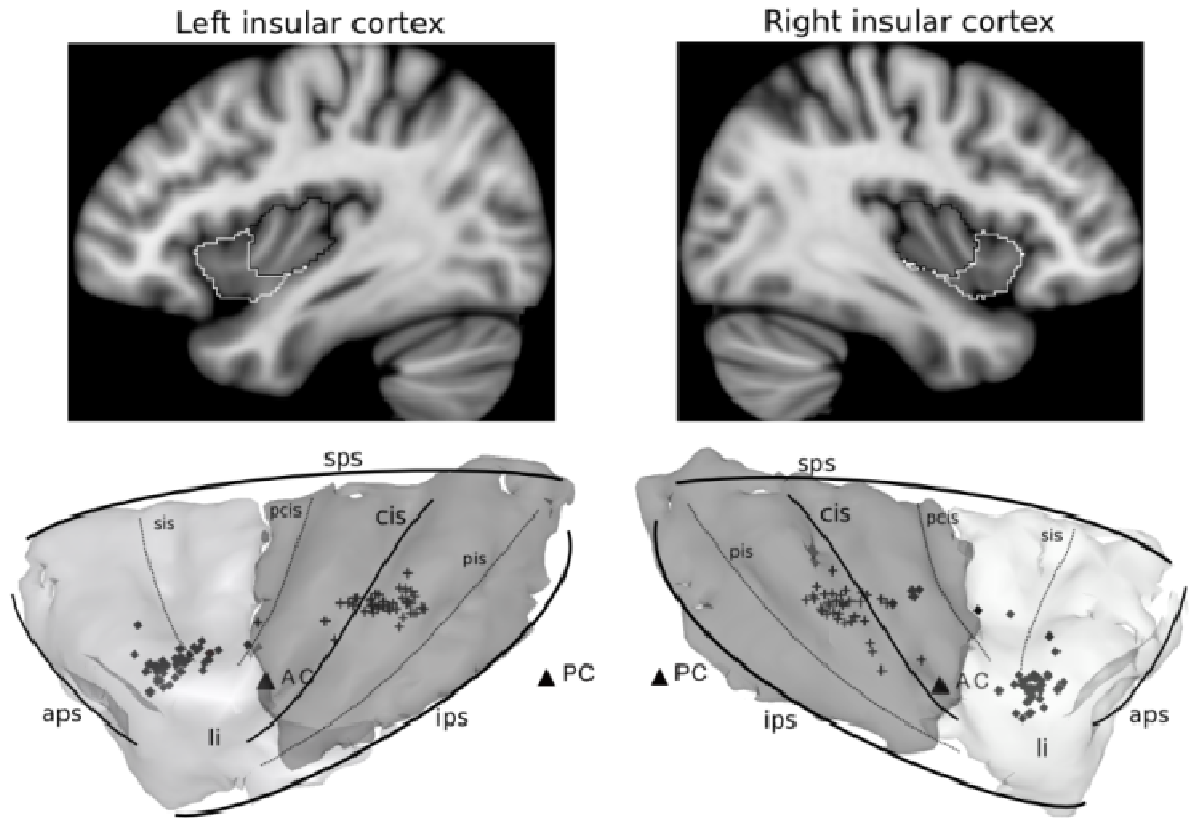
Connectivity-based clusters of the human insular cortex. Top row: sagittal T1-weighted MR image overlaid with the connectivity-based cortical subdivisions averaged through 40 subjects. Black outline: posterior insula (PI), white outline: anterior insula (AI). Bottom row: three-dimensional mesh representing the averaged anterior (white) and posterior insular connectivity clusters, overlay: major insular sulci. Rectangle markers: center-of-gravity points of the AI subdivision of individual subjects in the standard stereotactical space, cross markers: center-of-gravity of the PI subdivision of individual subjects.
